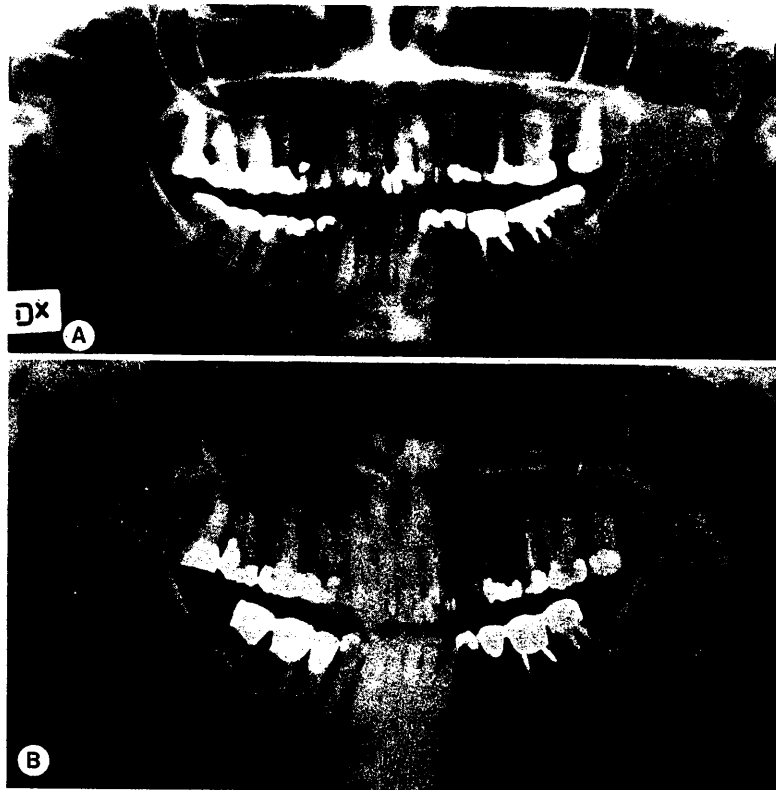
Orthopantomograms before (A) and after (B) treatment with prosthodontics to maintain disk in recaptured position. Same patient as in Fig. 4.
